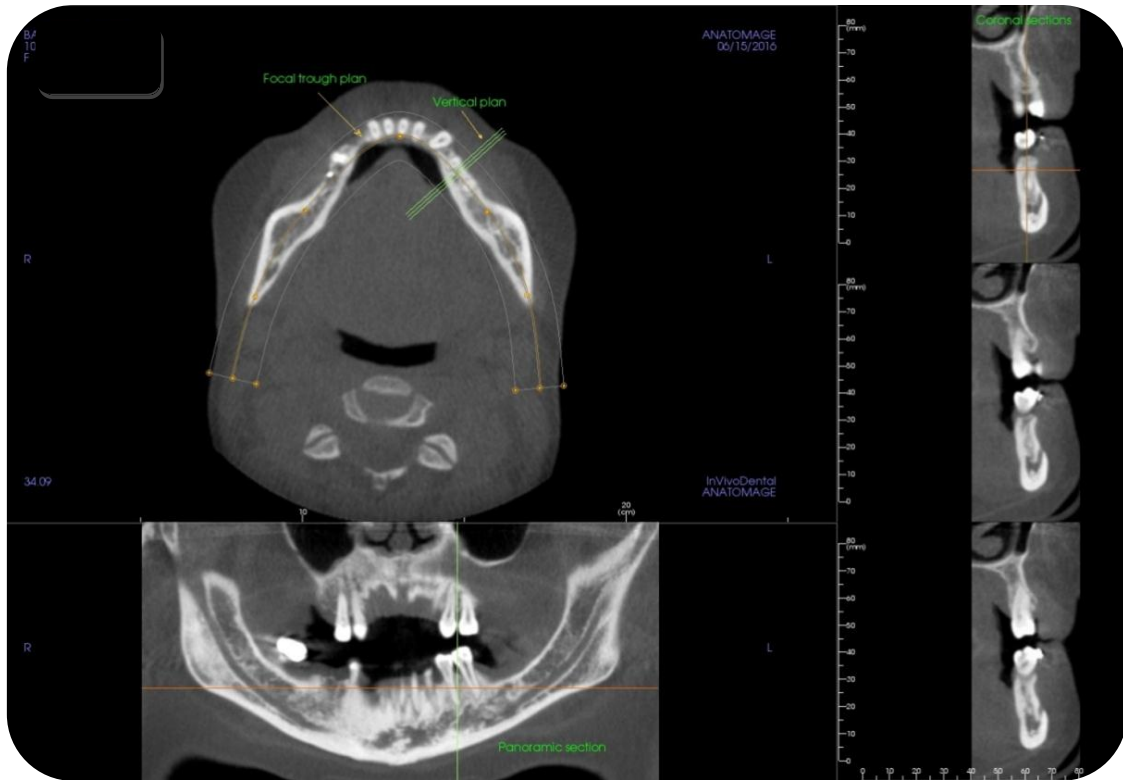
Arch Section option; Above: The axial section. Below: The panoramic section. Left side: 3 cross sectional windows (Images obtained with i-CAT® Model 17-19; CBCT Imaging Unit: InVivoDental5 Version 5.2 Anatomage, software): Deneomaxillofacial Radiology Department; Faculty of Dentistry- University of Yeditepe.
